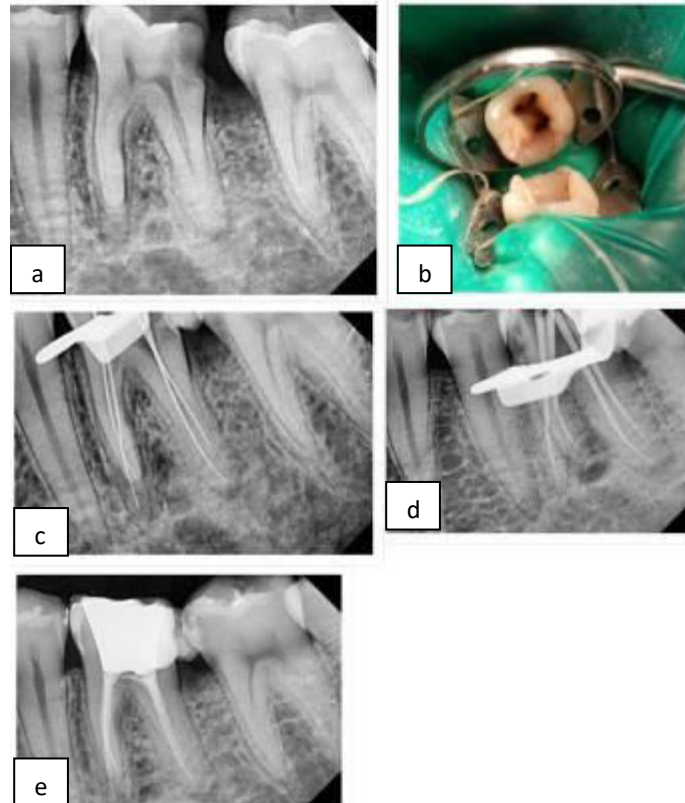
a) Preoperative Radiograph irt #36; b) Clinical Photograph irt #36; c) Working length radiograph irt #36; d) Mastercone radiograph irt #36; e) Postoperative radiograph irt #36.
